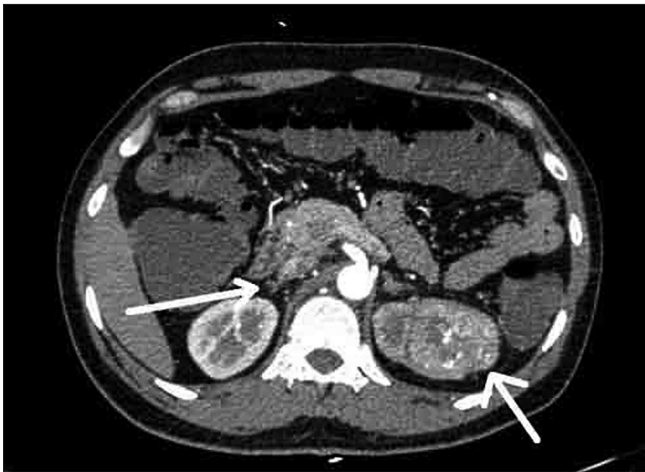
Computed tomography scan of the abdomen showing left renal mass and right adrenal mass
